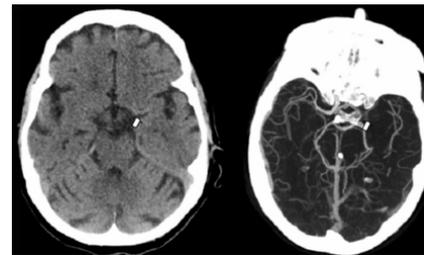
Axial 30-mm MIP CTA showing the MCA anatomy (left): terminal ICA (black arrow), M1 MCA (white arrow), M2 MCA (grey arrows). Example case (right) of a left M1 MCA occlusion.
